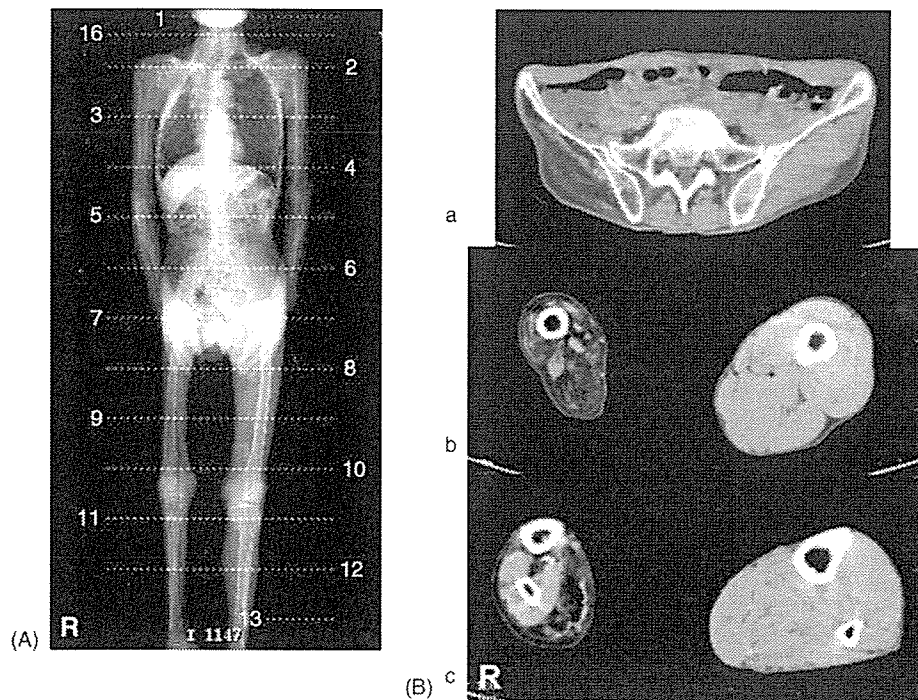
CT findings. (A) Shows a full body image. (B) Shows transverse sections at the levels of the inferior pelvis (a), mid-thigh (b), and mid-calf (c). The right leg is shorter. Severe atrophy and fatty degeneration are seen from the right hip through the leg.
